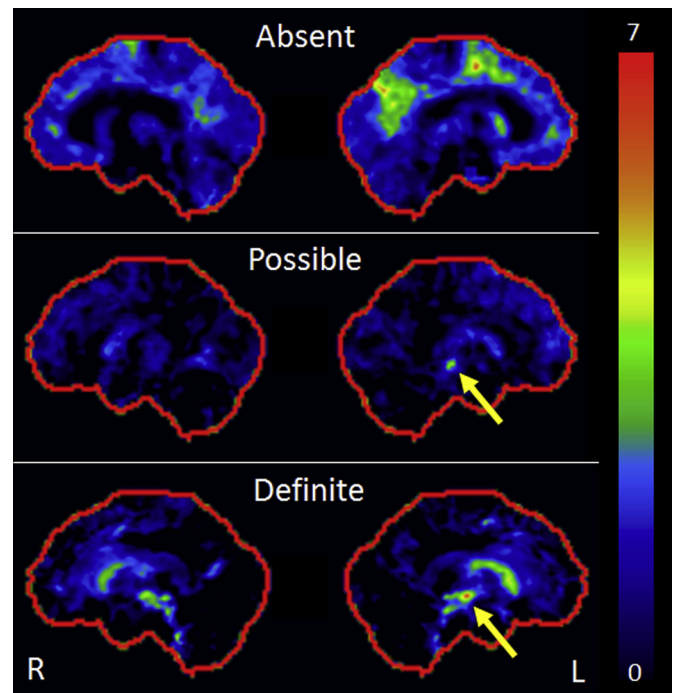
FDG-PET imaging showing examples of ‘absent’, ‘possible’ and ‘probable’ pimple signs.
